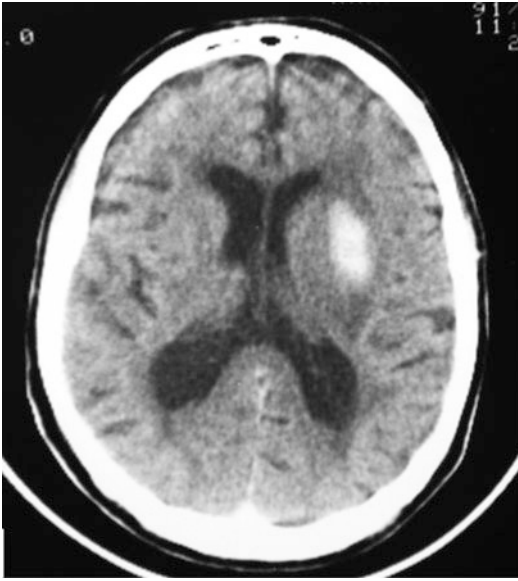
CT scan shows basal ganglia haemorrhage
